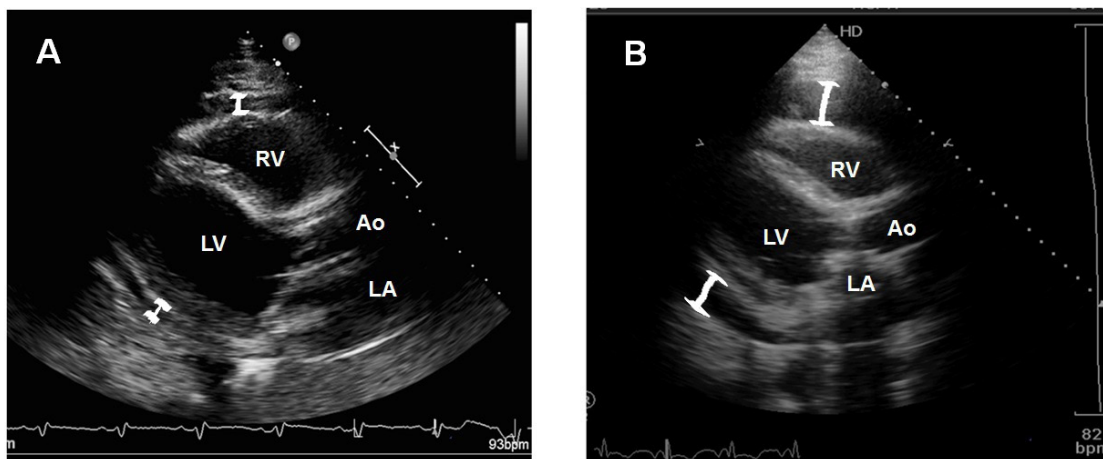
(A) Small pericardial effusion (< 10 mm) and (B) Large pericardial effusion (≥ 10 mm) on the postoperative echocardiographic examination. RV: right ventricle, LV: left ventricle, Ao: Aorta, LA: left atrium.
